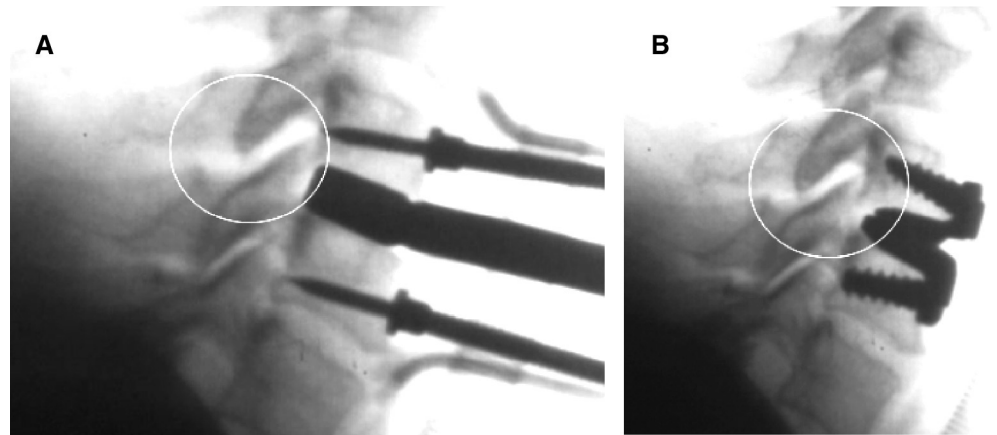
Lateral C-spine x-ray in a case of intradiskal overdistraction resulting in overdistraction of the facets before (A) and after (B) implant placement.
